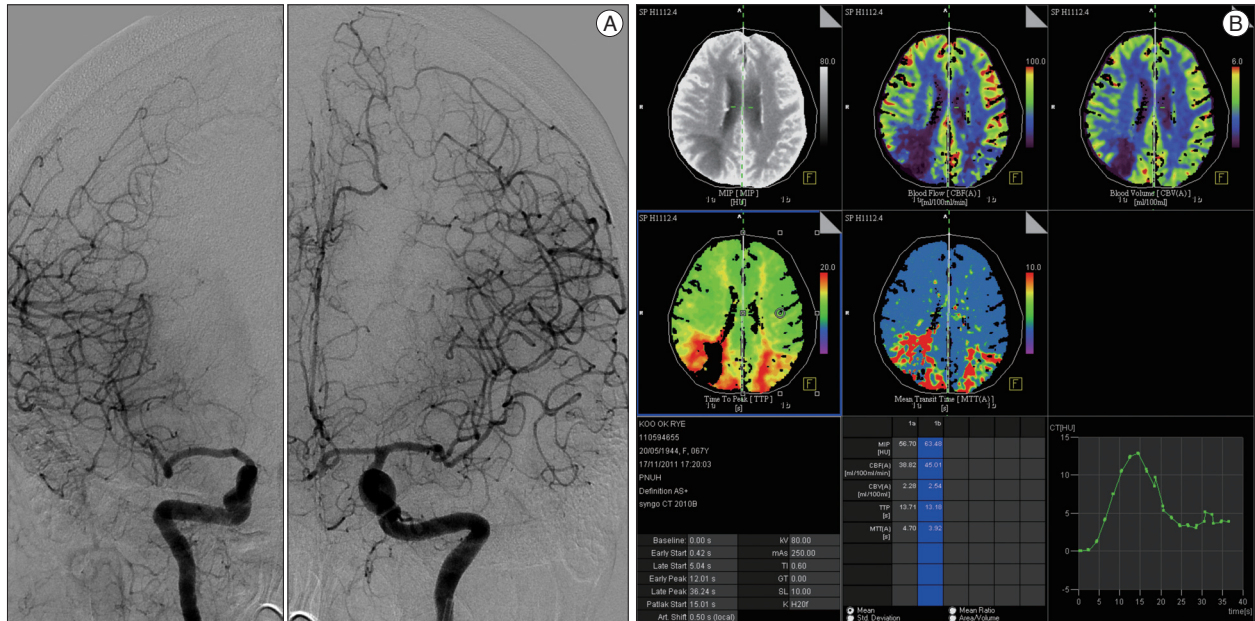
A : Conventional cerebral angiogram demonstrating diffuse cerebral arteries vasospasm, predominantly at the right middle cerebral artery. B : CT perfusion image demonstrating perfusion in both occipital and temporal lobes.
